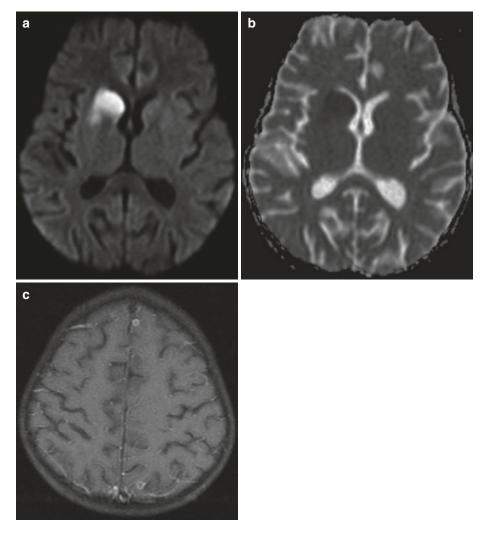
Acute infarct in the right basal ganglia is seen hyperintense on diffusion-weighted MRI (a) and hypointense on ADC image (b). In addition, there are some
